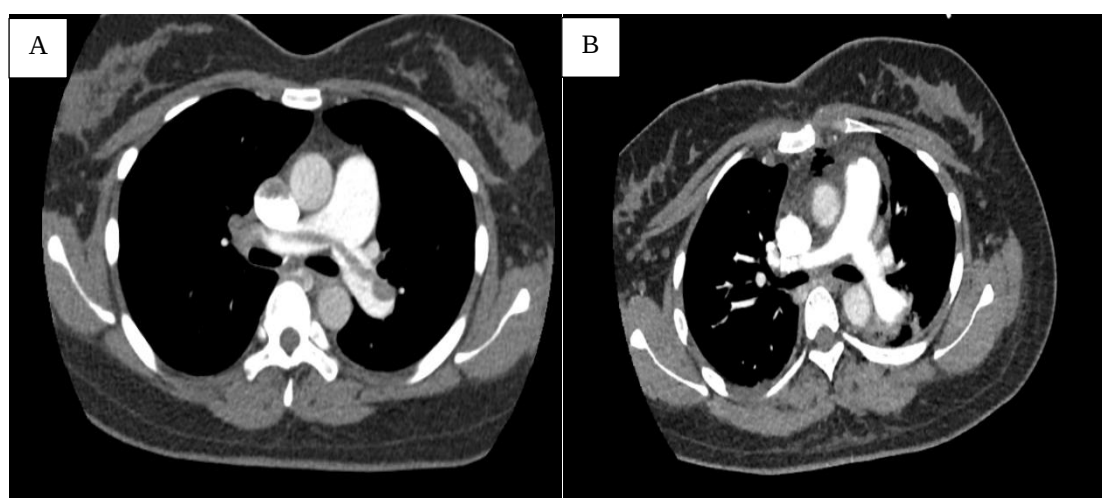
CT Pulmonary Angiogram. (A, right) Axial section demonstrating thrombi at the bifurcation of the right and left main pulmonary arteries with oligemic lung fields, indicative of a high clot burden. (B, left) Postoperative axial CT showing complete thrombus removal and restoration of bilateral pulmonary blood flow
